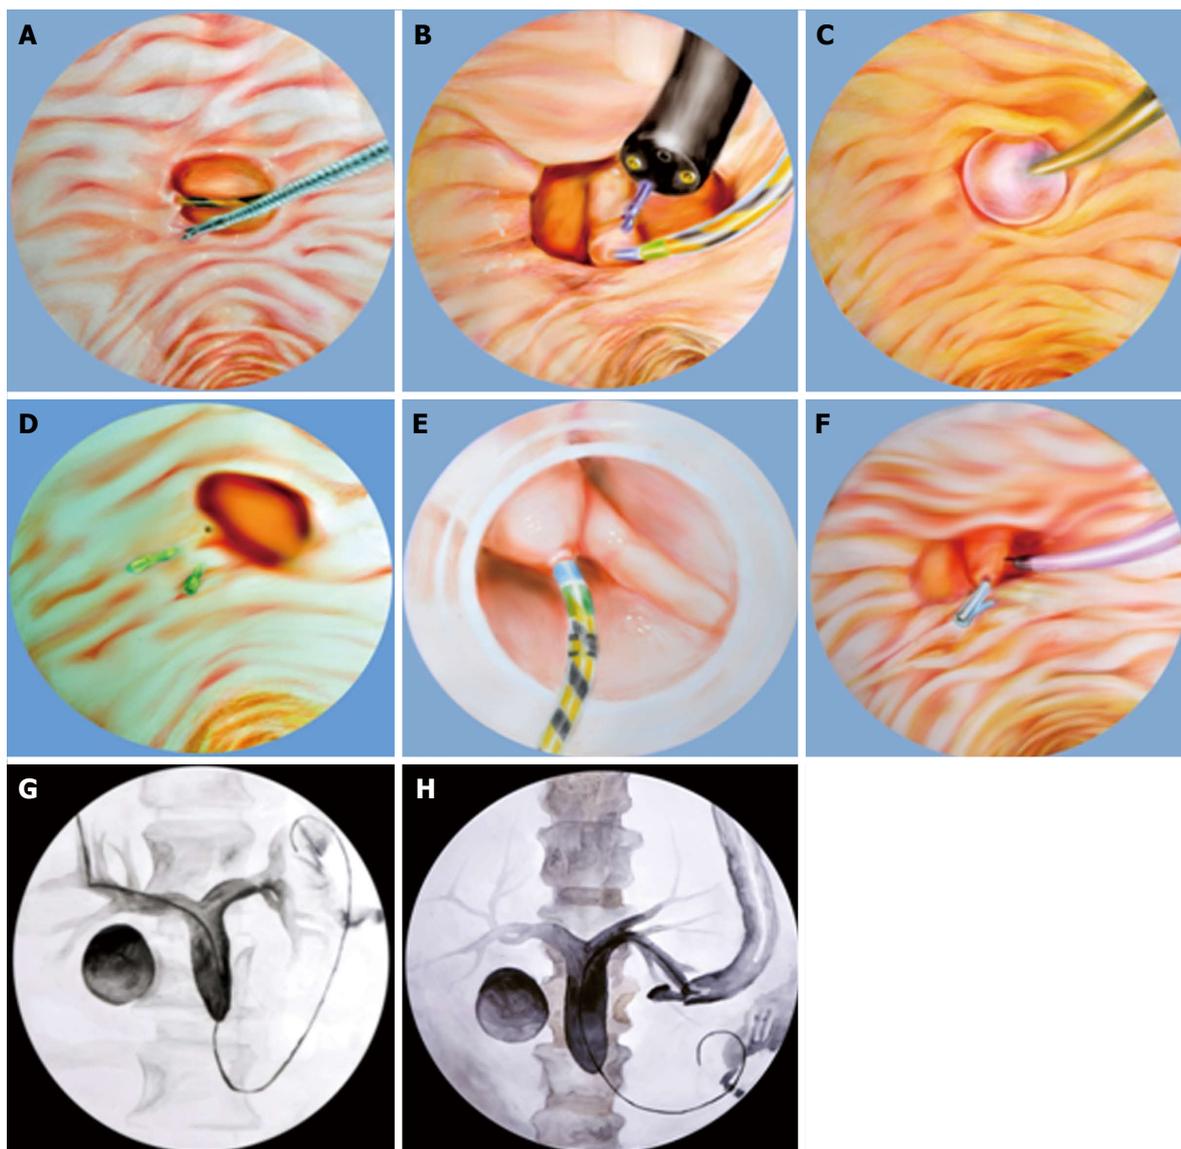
Techniques for difficult cannulation. A: Two-devices in one-channel method; B: Double endoscope method; C: Balloon dilation of the narrow diverticular neck; D: Endoclip-assisted cannulation; E: Cap-assisted cannulation; F: Pancreatic duct stent placement followed by pre-cut biliary sphincterotomy; G: Percutaneous ultrasound-guided rendezvous technique; H: Endoscopic ultrasound-guided rendezvous technique.
